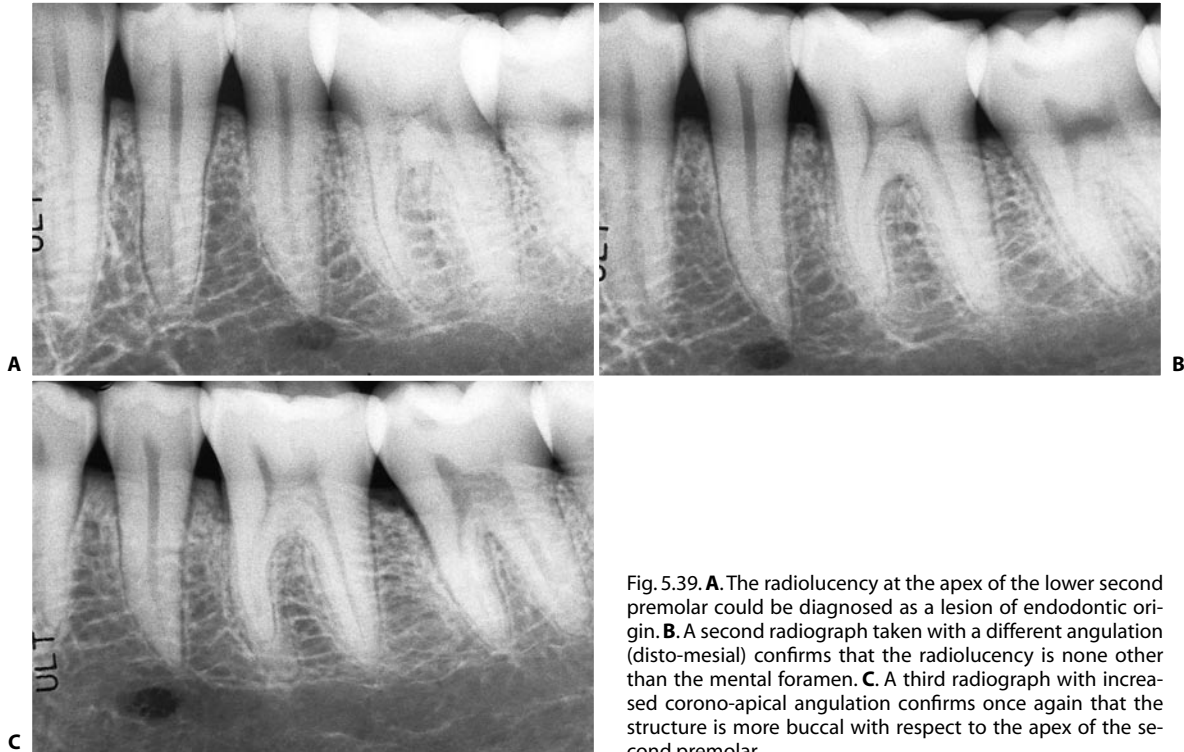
A. The radiolucency at the apex of the lower second premolar could be diagnosed as a lesion of endodontic origin. B. A second radiograph taken with a different angulation (disto-mesial) confirms that the radiolucency is none other than the mental foramen. C. A third radiograph with increased corono-apical angulation confirms once again that the structure is more buccal with respect to the apex of the second premolar.
